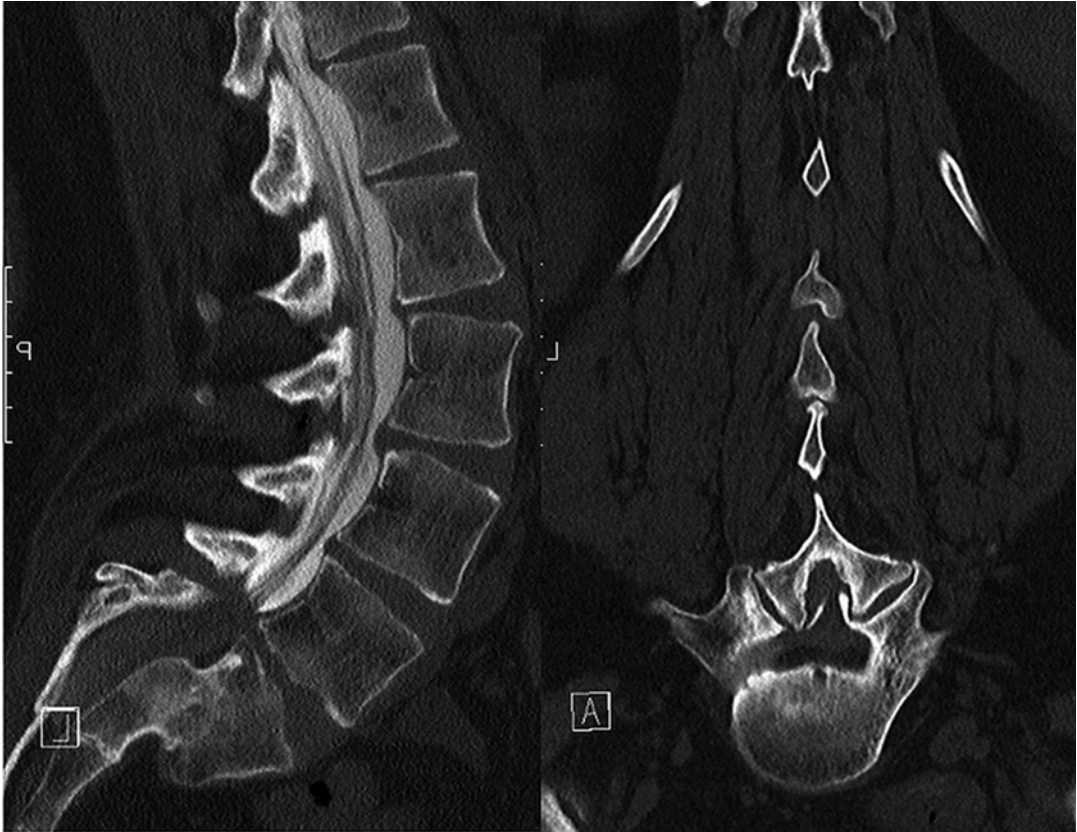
CT scan:* showing advanced spondyloptosis with autofusion at the L5/S1 level
